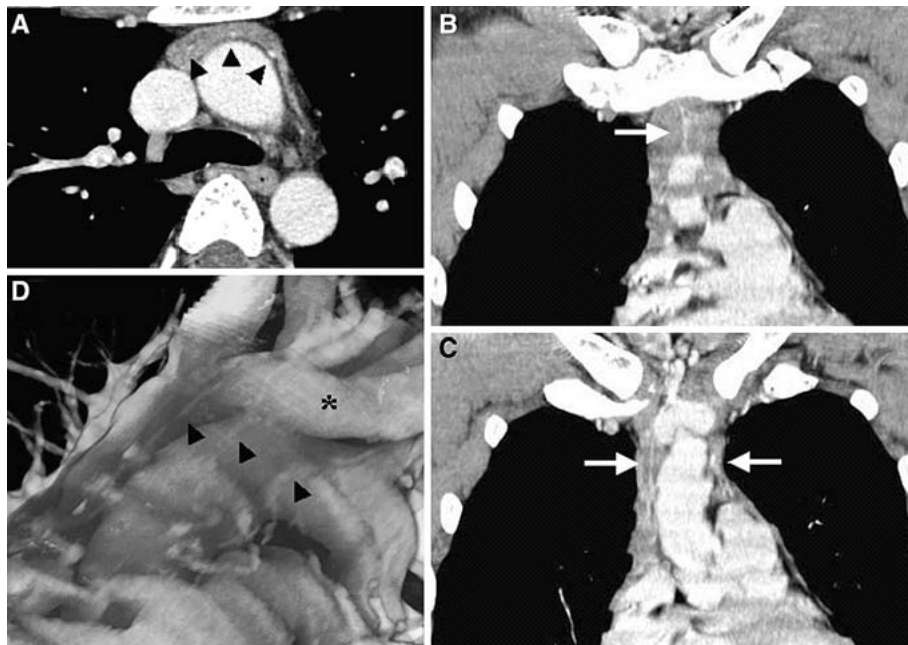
Eight-channel multidetector-row computed tomography (MDCT) images obtained from patient 1 (Table 1). A Horizontal two-dimensional image showing three thymic veins in the thymus gland (black arrowheads). B, C These veins also are identified in coronal images (white arrows): C is dorsal to B. D Reconstructed three-dimensional image clearly demonstrating how thymic veins (black arrowheads) are draining into the left brachiocephalic vein (*).
